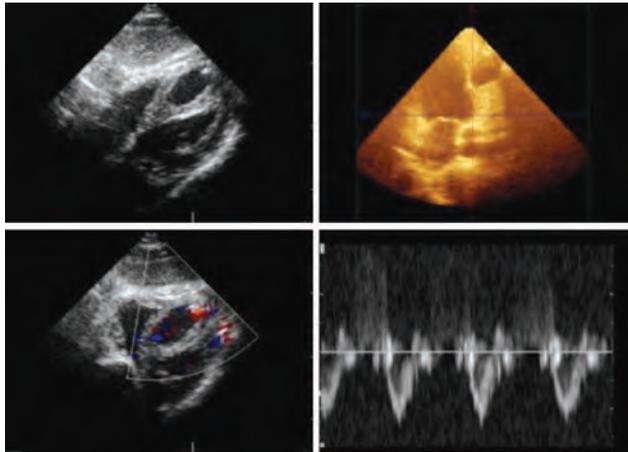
2D and 3D transthoracic echocardiogram.
